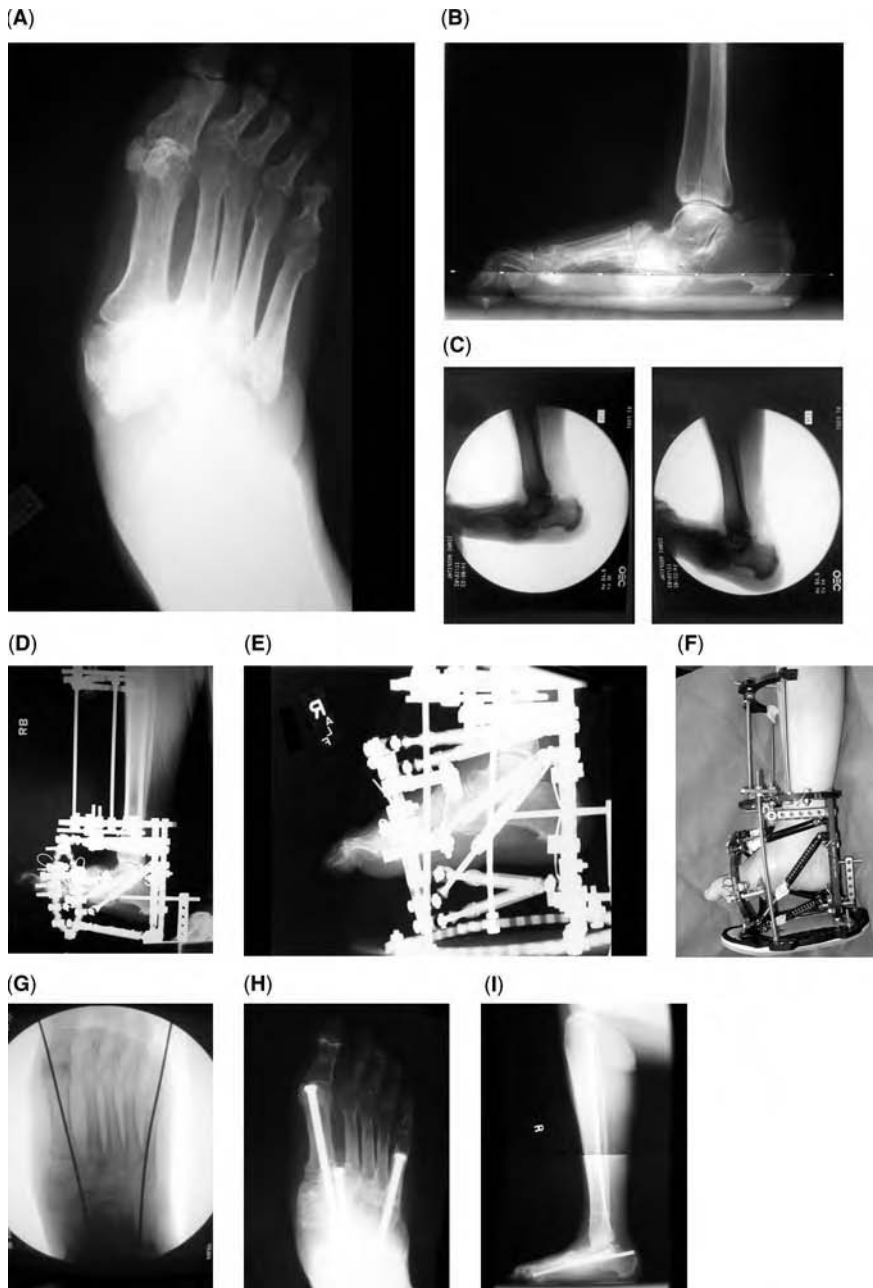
Case of midfoot Charcot neuroarthropathy with hindfoot equinus deformity (Eichenholtz stage 3, stable, without ulceration, or osteomyelitis). (A) Anteroposterior view radiograph shows the patient during weight bearing. Note the midfoot abduction. (B) Lateral view radiograph shows the patient during weight bearing. Note the dorsal translation midfoot deformity with equinus. (C) Percutaneous Achilles tendon Z-lengthening was performed to acutely correct the hindfoot equinus deformity. A lateral view still image obtained by using video fluoroscopy shows the complete correction of the equinus deformity. The hindfoot and ankle were then fixed in the corrected position with the Taylor spatial frame (forefoot 6 × 6 butt) (Smith & Nephew, Memphis, Tennessee, U.S.A.). (D) Lateral view postoperative radiograph shows the initial forefoot position. (E) Lateral view postoperative radiograph shows the forefoot position after gradual distraction to realign the forefoot to the hindfoot. (F) Clinical photograph shows the final midfoot realignment. Immediately after the external fixator was removed, a minimally invasive fusion of the midtarsal joint was performed. (G) Intramedullary metatarsal cannulated screws were inserted percutaneously to stabilize both the medial and the lateral columns of the foot. (H) Anteroposterior view radiograph shows the patient during weight bearing. Note the accurate anatomic reduction. (I) Lateral view radiograph shows the patient during weight bearing. Note the accurate anatomic reduction. The patient has not experienced a recurrence of ulceration or deformity (four-year follow-up).
